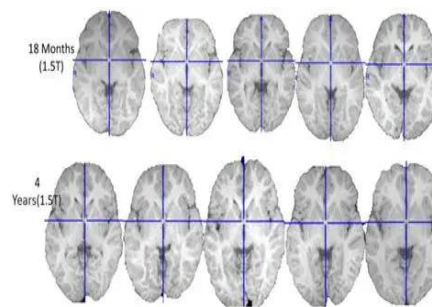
Neurological age of 18 months to 4 years from structural MRI data.
